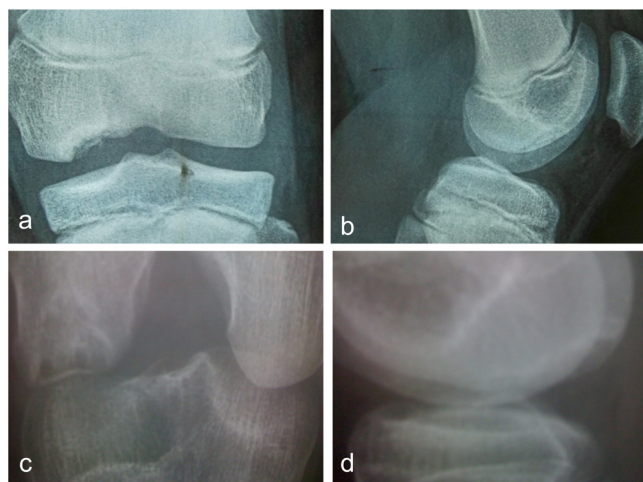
Evaluation of OCD lesion with X-Rays.
